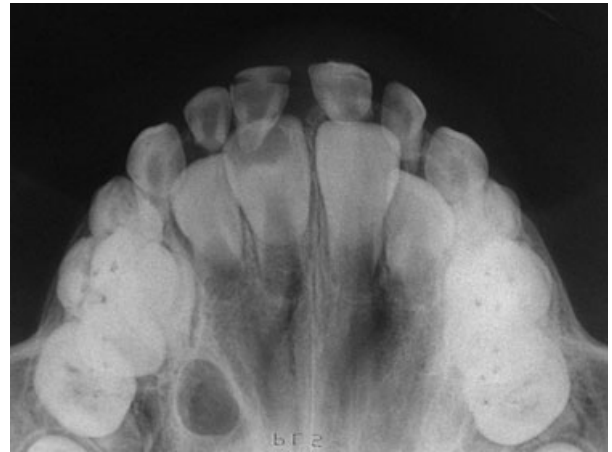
Occlusal radiograph confirming the presence of a periapical lesion associated with the replanted maxillary right primary central incisor, and the beginning of root formation of permanent teeth.
